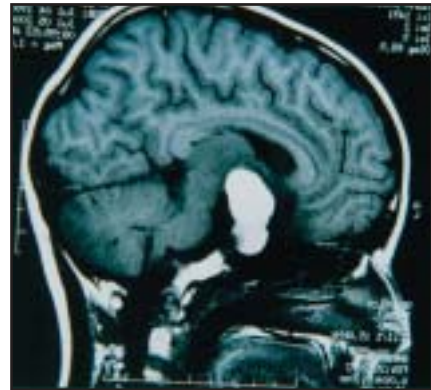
MRI of infused brain.
